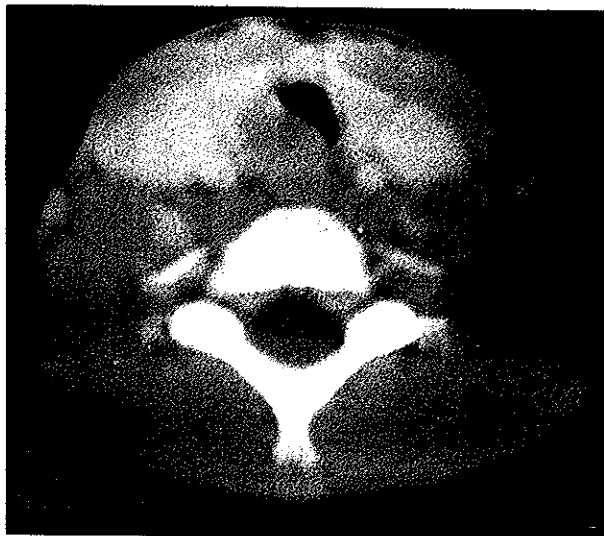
Computed tomography scan of the neck (case #2) shows a subglottic mass with subglottic narrowing.
